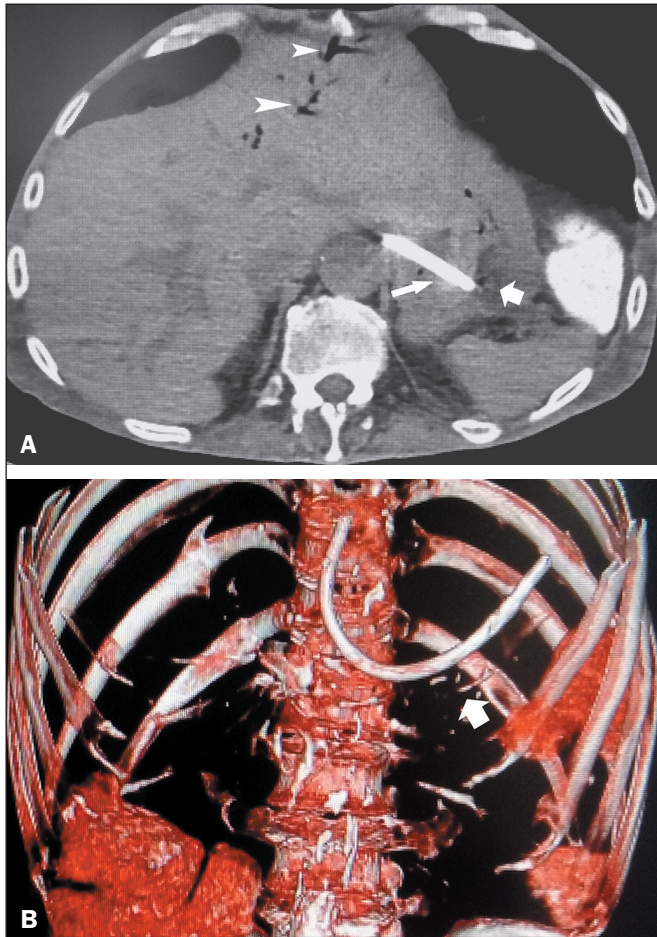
A 48-year-old male psychiatric patient who ingested a portion of an aerial television cable. A: Axial CT image showing the foreign object (thin arrow) that has penetrated the stomach wall. An air bubble is seen at the distal tip of the tubular item (thick arrow). Air in the intrahepatic bile ducts (arrowheads) in the left hepatic lobe implies penetration of the left bile duct during attempted swallowing of the cable. B: Coronal volume-rendering CT image (vessel view) showing the curvilinear cable (arrow) situated in the upper abdomen.
